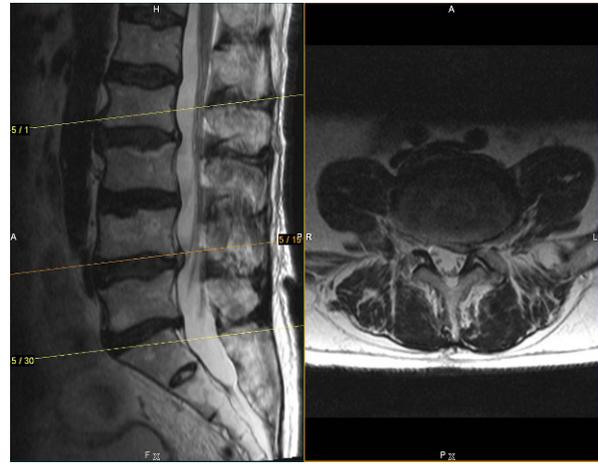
Magnetic resonance imaging of the thoracic and lumbar spine with contrast medium enhancement. No pathological alterations could be seen at the thoracic-lumbar transition.
